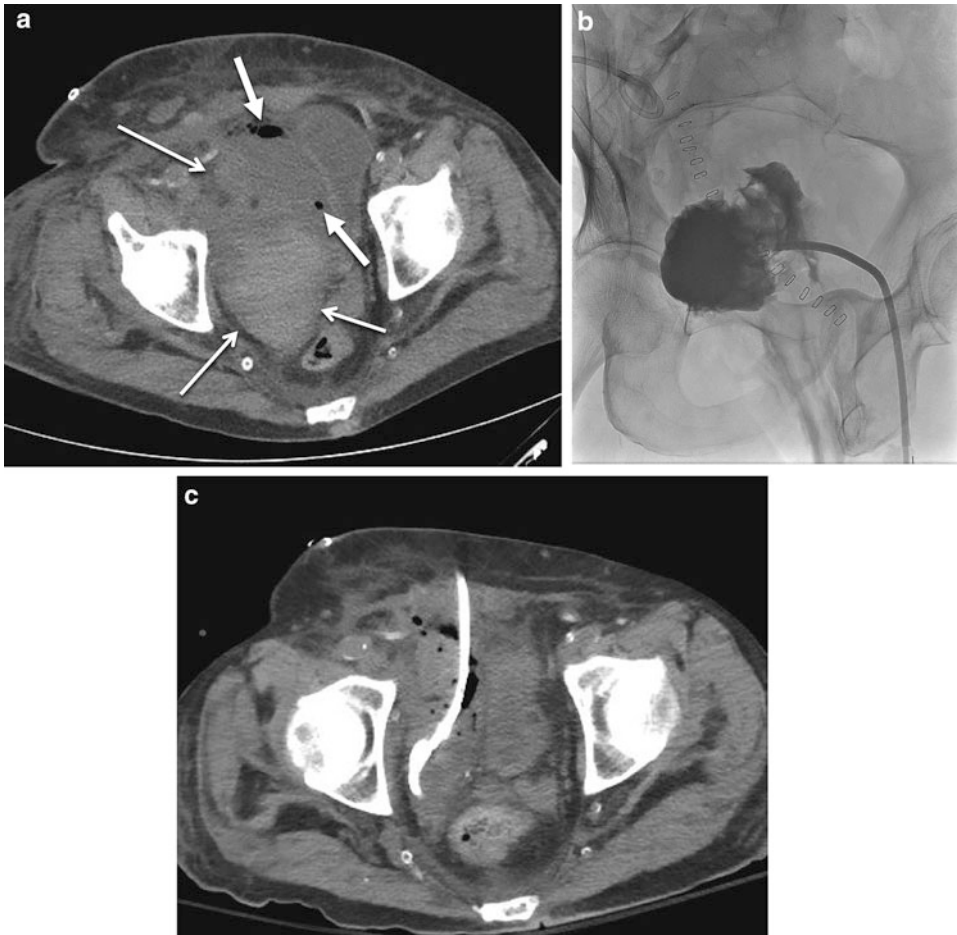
Infected hematoma. (a) Axial unenhanced CT image shows a heterogeneous fluid collection (*arrows*) with layering dense material typical of a hematoma with punctate foci of gas (*thick arrows*) indicating infection displacing the bladder laterally (*asterisk*). (b) Fluoroscopic image obtained following ultrasound-guided drainage
